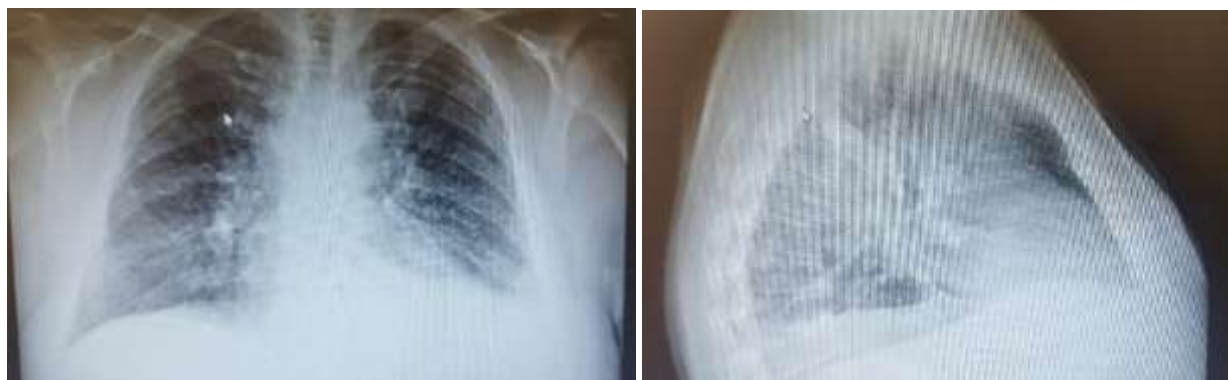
A chest x-ray with frontal (1) and lateral (2) view showing miliary disseminated lung disease, hilar lymphadenopathy and left sided pleural effusion
